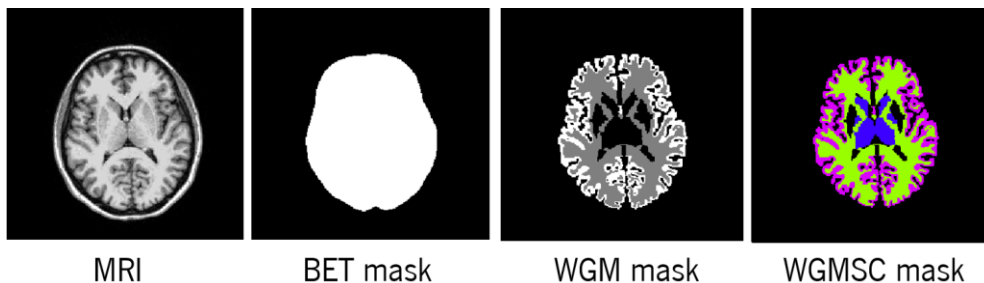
Example of a case of Human's Dataset. An MRI axial slice and its respective labels.
